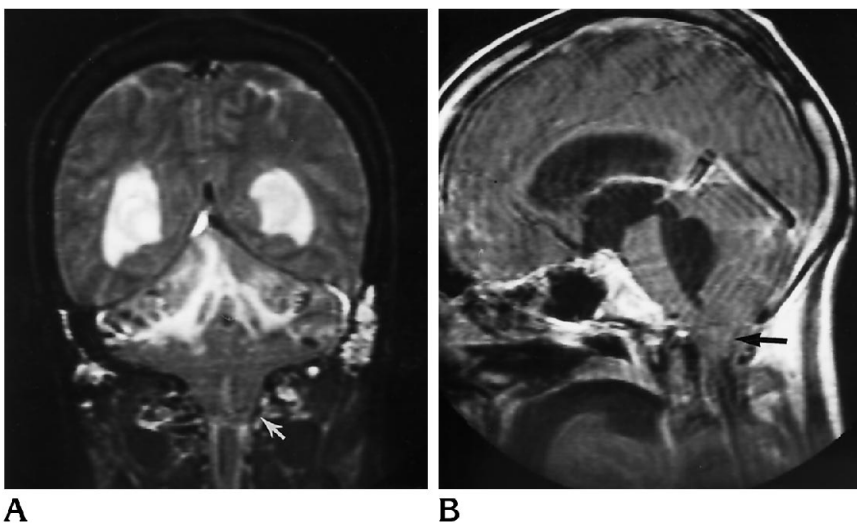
A, T2-weighted coronal image after placement of a paraspinous lumbar drain after scoliosis surgery shows hemorrhagic infarction, ventricular enlargement, and herniation of the cerebellar tonsils (arrow).
